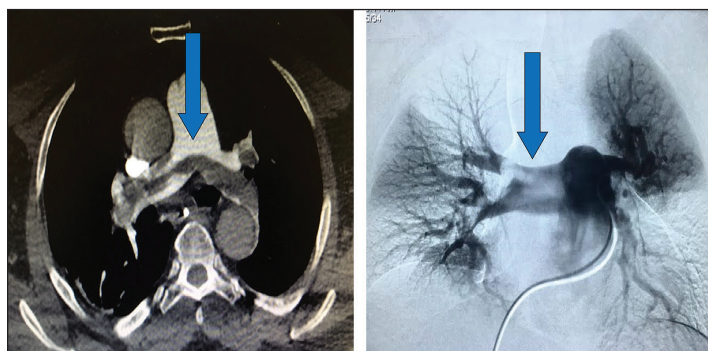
CT scan and pulmonary angiogram.
